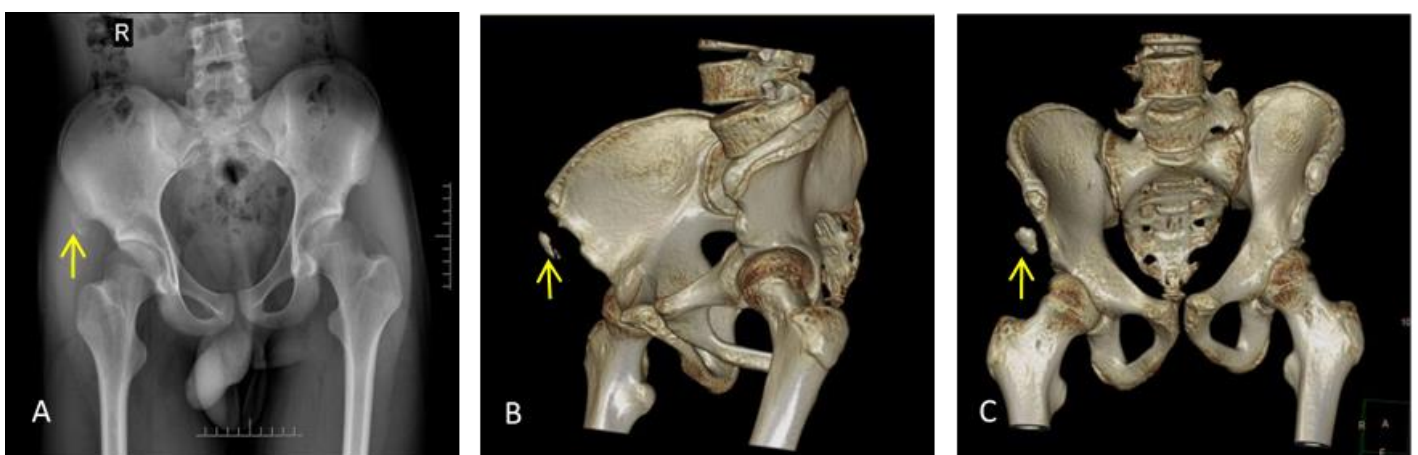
A, B and C show typical anteroposterior/axial X-ray and 3-dimensional computed tomography obtained after the patient is injured.
